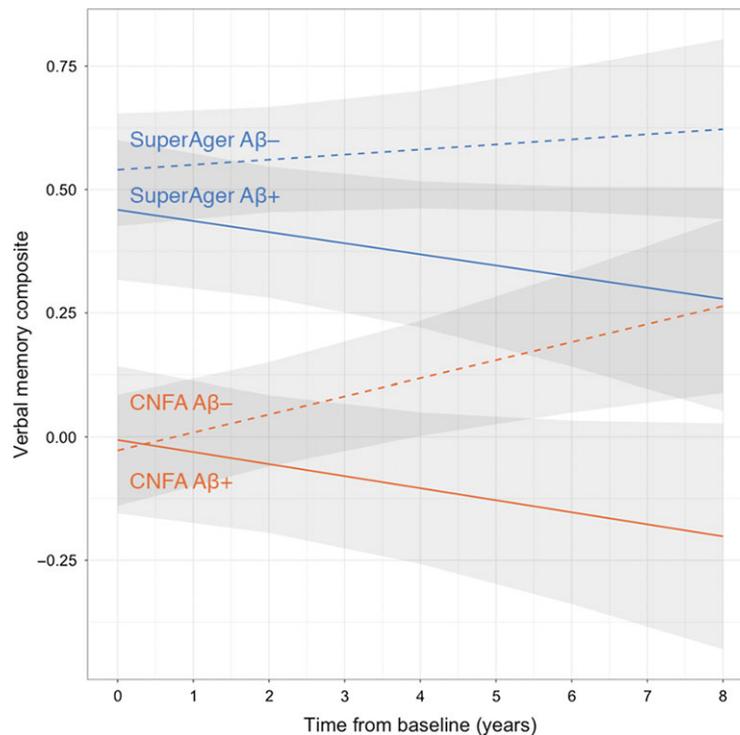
Verbal memory performance over time by SuperAger and A β status. Abbreviations used: A β - = cerebral amyloid-beta within normal range (PET SUVR < 1.40); A β + = elevated cerebral amyloid-beta; CNFA = cognitively normal for their age.
